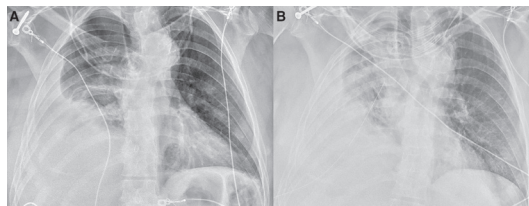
(A) Initial chest X-ray reveals a large right-sided hemothorax. (B) Subsequent chest tube placement resulted in 1.2 L of output but no resolution of hemothorax on plain radiograph.
